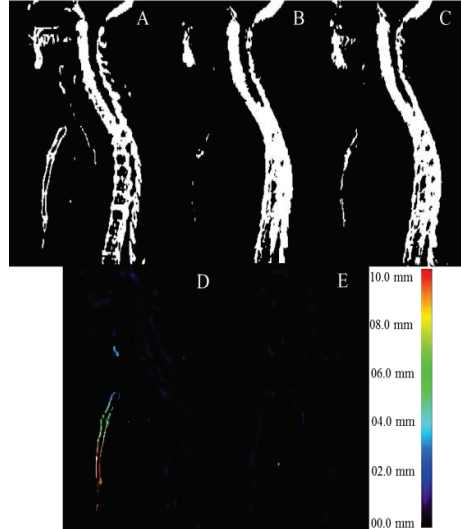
Representative slice of bone segmentation from MR image. A) Binary image of segmented bone from CT image B) segmented bone obtain from Hofmann pseudo-CT generation algorithm C) Segmented bone utilizing the new method D) Distance error map calculated from comparison of Hofmann pseudo-CT and E) new approach with the reference bone segmented on the CT image.
